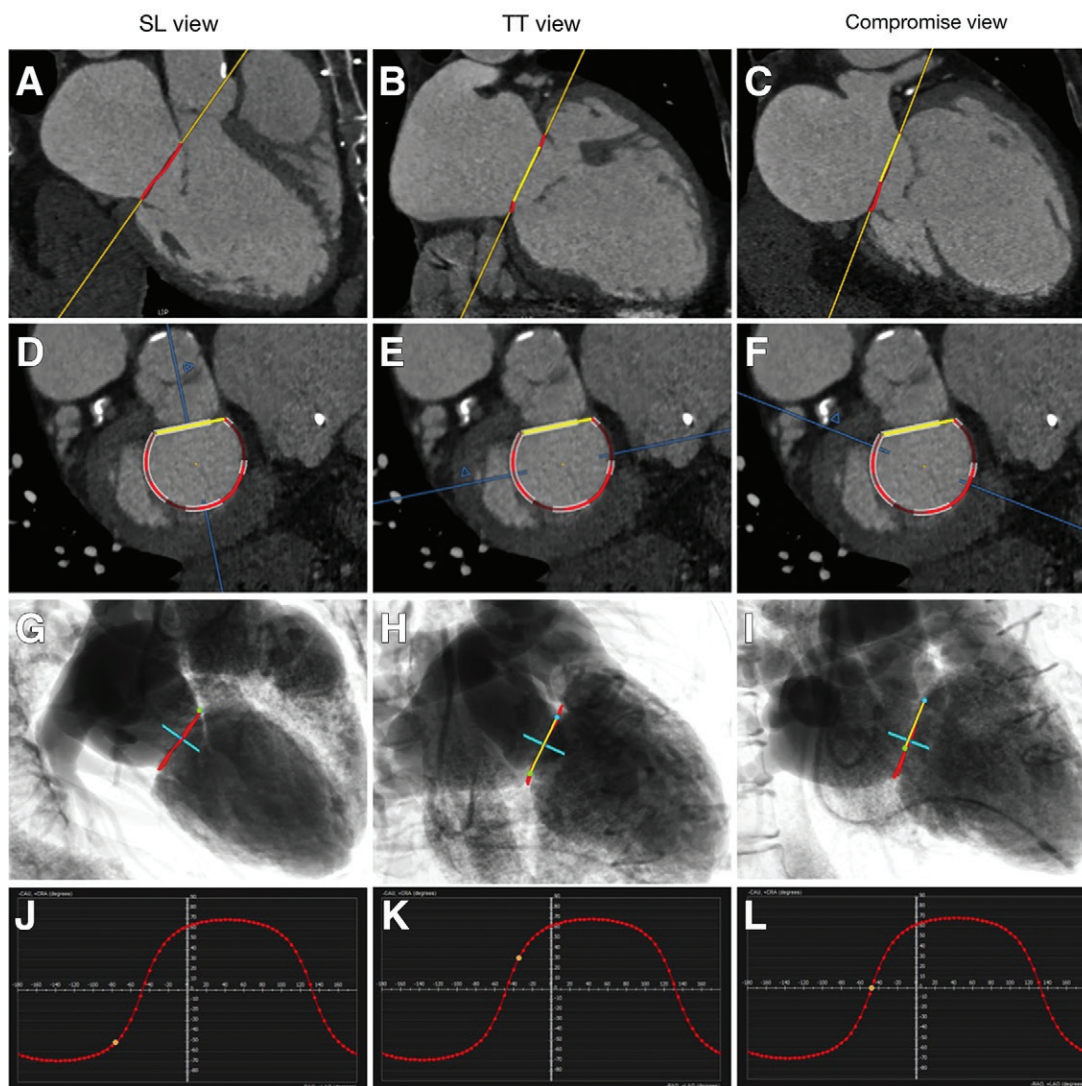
Prediction of fluoroscopic angulation for coplanar deployment. A–C, Long-axis views of the mitral valve obtained aligned to the septal-lateral line (*SL*), trigone-to-trigone line (*TT*), and the commonly used compromise view. D–E, Annular views, with the blue line demonstrating how A–C views intersect the annulus. G–I, Images show how these views would appear on invasive angiograms based on three-dimensional CT data. J–L, Images demonstrate the sinusoidal path the c-arm would follow as it rotates around the patient to always provide a tangential valvular view, with the x-axis describing the LAO-RAO tilt required and the y-axis describing the CRA-CAU tilt required. The yellow dots demonstrate where each of the A–C views lie on this axis. LAO = left anterior oblique, RAO = right anterior oblique, CRA = cranial, CAU = caudal.
